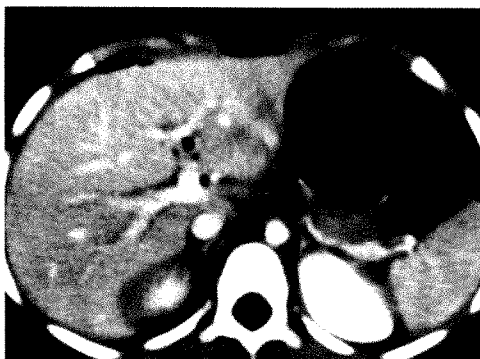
Pneumoperitoneum noted on CT scan was not recognized on supine abdominal radiograph in this 5-year-old girl who was involved in a motor vehicle accident while wearing a lap belt. CT findings include free air anterior to the liver and air and fluid tracking along left portal vein. At surgery a 1.5-cm jejunal perforation was found.
